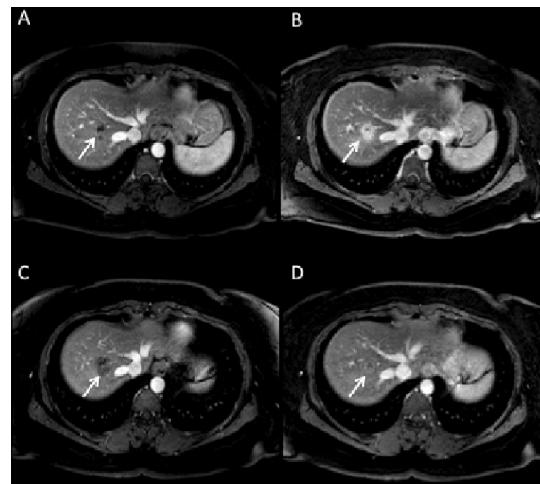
Axial T1-weighted images of the liver. An example of a CRLM that is hypoenhancing on portovenous phase (A) and hyperenhancing on delayed phase (B) with gadobutrol, but hypoenhancing on both portovenous (C) and delayed phase (D) with gadofosveset
